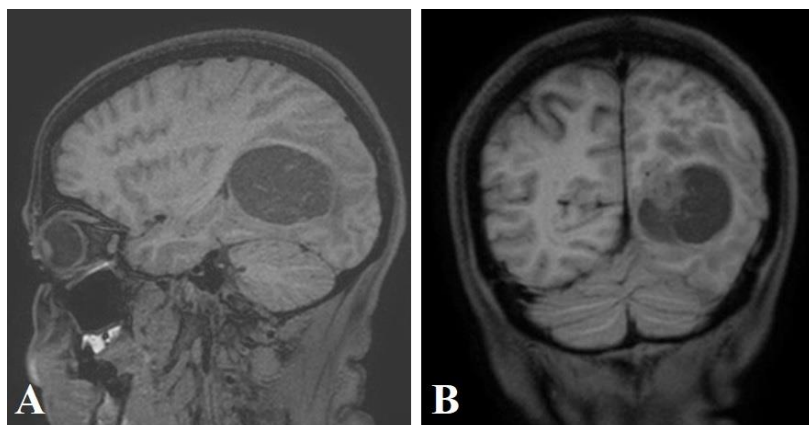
Sagittal (A) and coronal (B) T1-weighted MRI images show a hypointense area in the left parieto-occipital lobe that appears as a hypointense lesion compared to the surrounding normal brain tissue.
